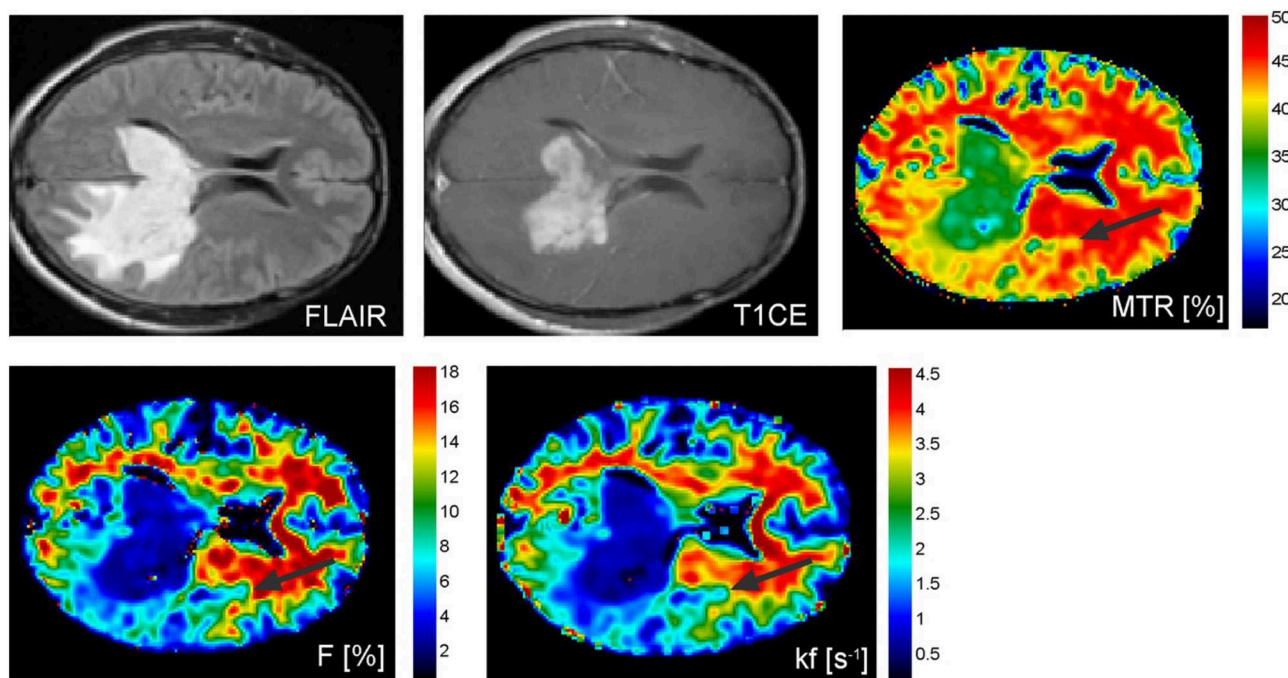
Conventional T2-FLAIR and T1-weighted contrast-enhanced as well as magnetization transfer ratio (MTR), macromolecular concentration (F), and exchange rate between the bound protons and free water protons (kf) images of a patient with a malignant pleomorphic glial tumor in the left temporal and occipital lobes showing contralateral tumor extension via the splenium of the corpus callosum. Abnormal MTR values can be discerned ventrally and laterally to the altered looking tissue on conventional MRI (black arrows). Reproduced, with permission, from Garcia et al. (35).
